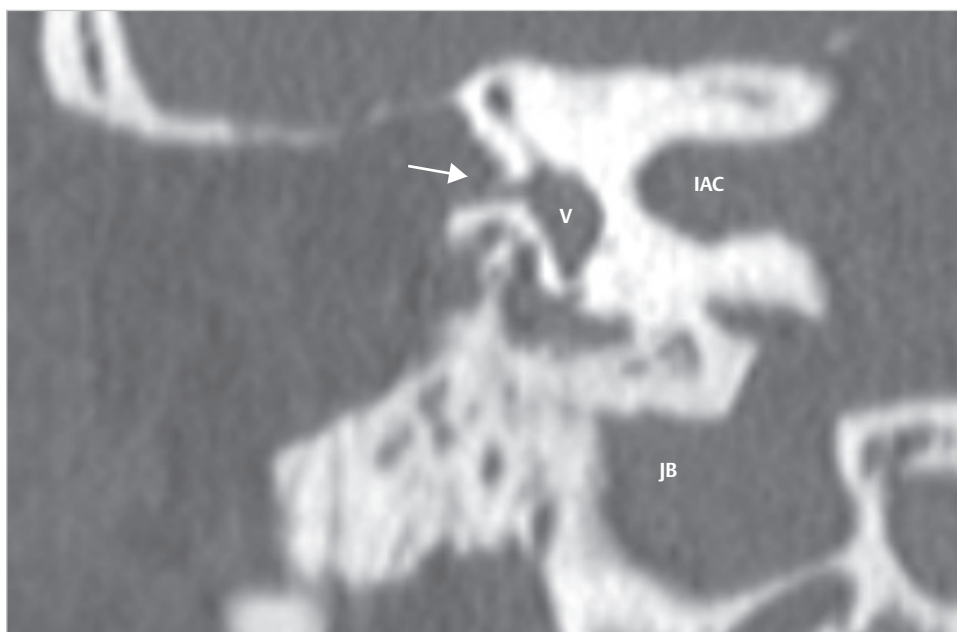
The coronal section of postoperative CT shows that the middle fossa plate is sufficiently thinned. The cavity is filled with abdominal fat. A large fistula is identified in the lateral semicircular canal (*arrow*). IAC, internal auditory canal; JB, jugular bulb; V, vestibule.
